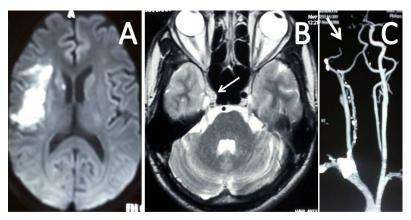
Homogenous Hyperintense intraluminal signal. Diffusion weighted-MRI (A) shows acute infarct in right middle cerebral artery territory. T2 Weighted-MRI (B) shows Homogenous hyperintense intraluminal signal in right ICA (arrow). CT Angiography of neck vessels (C) shows complete occlusion of right cervical ICA at the origin (arrow).
